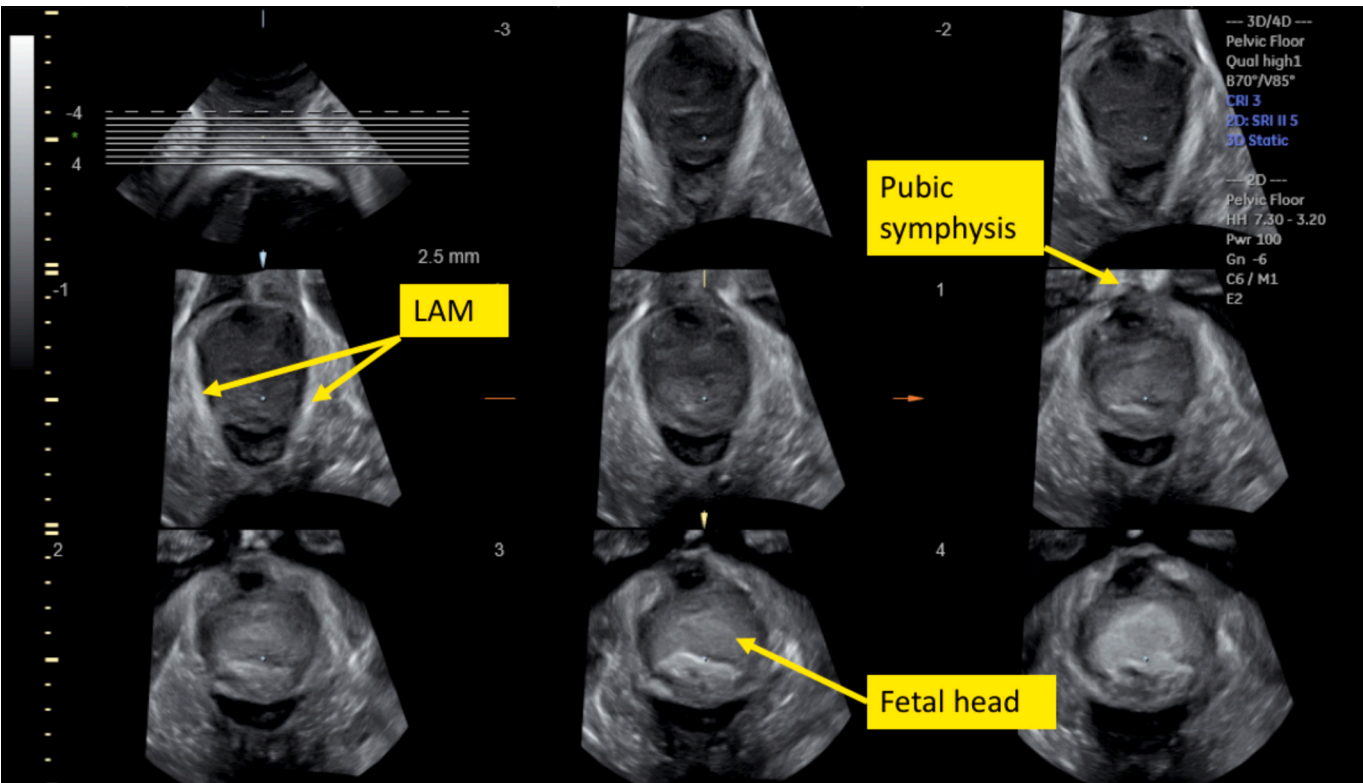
Transperineal tomographic ultrasound imaging: intact levator ani muscle during the second stage of labour.
